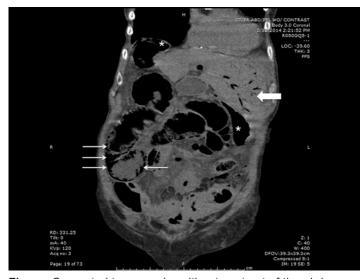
Computed tomography without contrast of the abdomen and pelvis showing free air (asterisks), pneumatosis intestinalis (thin arrows), and hepatic portal venous gas (large arrow).
